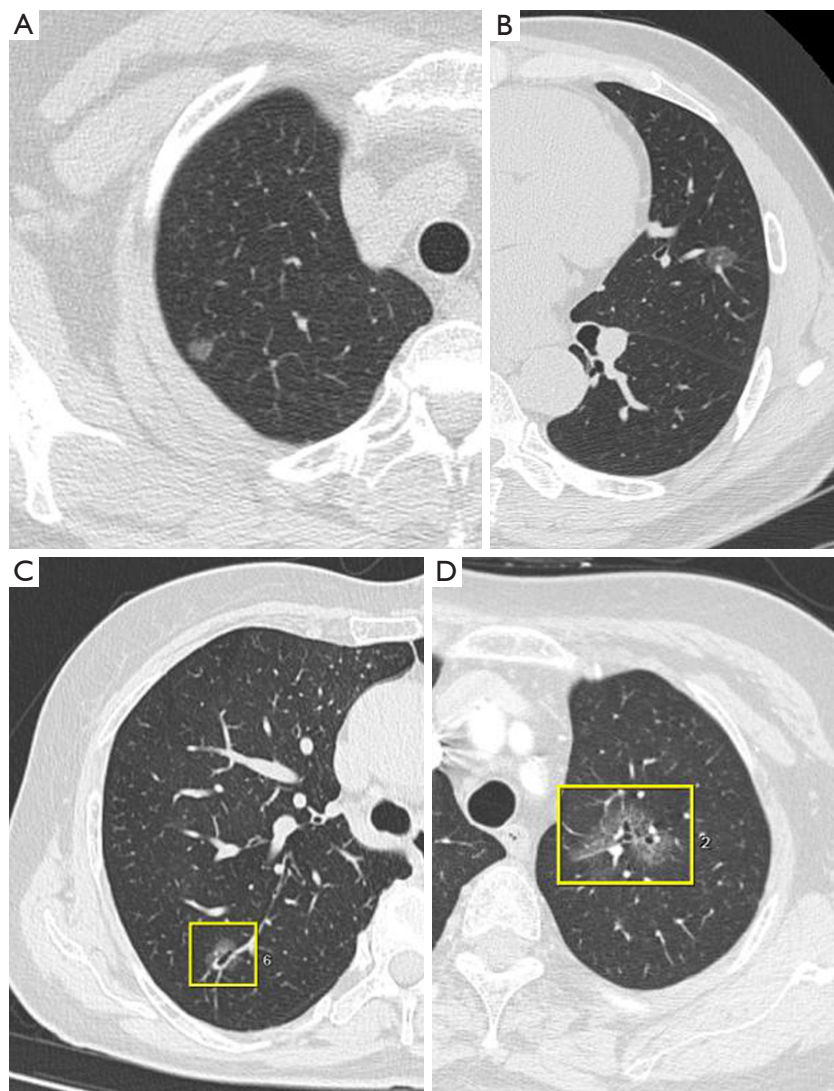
CT imaging features. (A) Female, 57 years old, AAH, round GGN in the apical segment of the right upper lobe of the lung, with a maximum cross-section of approximately 0.6 cm × 0.7 cm and clear borders. (B) Male, 46 years old, AIS, frosted glass nodule in the inferior lingual segment of the upper lobe of the right lung, measuring approximately 1.3 cm × 1.1 cm, with the lesion partially encircling a blood vessel. (C) Female, 69 years old, MIA, a partial solid nodule in the posterior segment of the upper lobe of the right lung, approximately 1.3 cm × 1.2 cm in size, with a visible inflated bronchial sign. Yellow box: a partial solid nodule. (D) Female, 71 years old, IAC, a partial solid nodule in the upper lobe of the right lung, approximately 3.0 cm × 2.1 cm in size, with visible air bronchogram. Yellow box: a partial solid nodule. CT, computed tomography; AAH, atypical adenomatoid hyperplasia; GGN, ground-glass nodules; AIS, adenocarcinoma in situ; MIA, minimally invasive adenocarcinoma; IAC, invasive adenocarcinoma.
